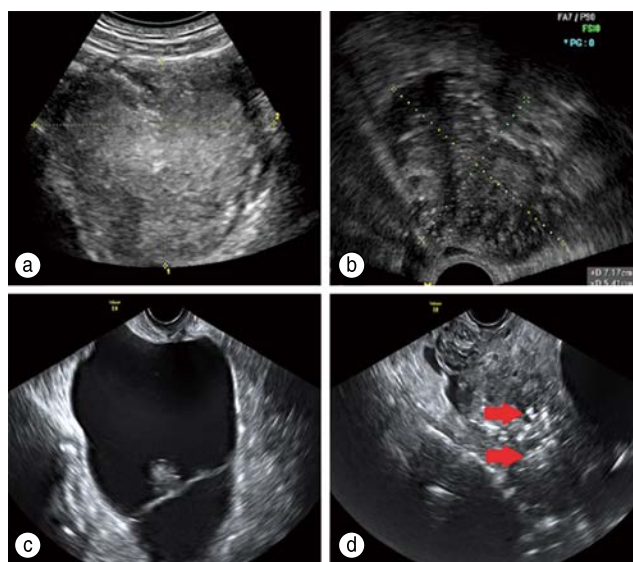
Ultrasonographic features of a brenner tumor. (a, b) The tumor body contains solid components; (c) There is no echo in the cystic fluid of the tumor; (d) Post-cyst signal shadow
